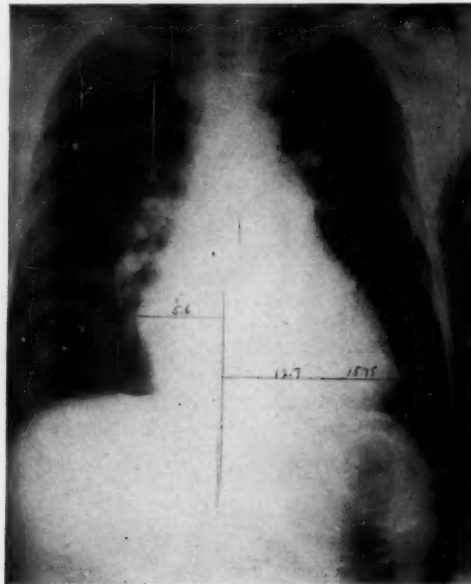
Roentgenogram of the chest, February 8, 1938, showing the enlargement of the size of the heart.
